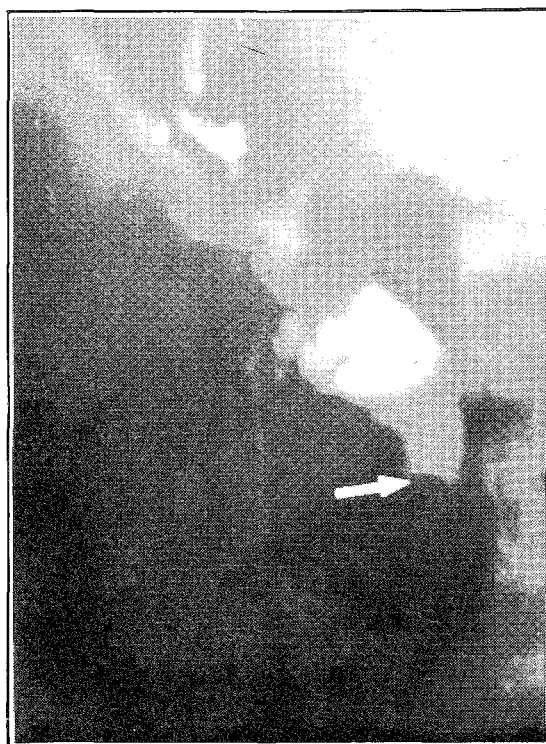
b) Operative cholangiogram confirmed the ultrasound appearances. The stone causing a filling defect within the duct (arrow).
